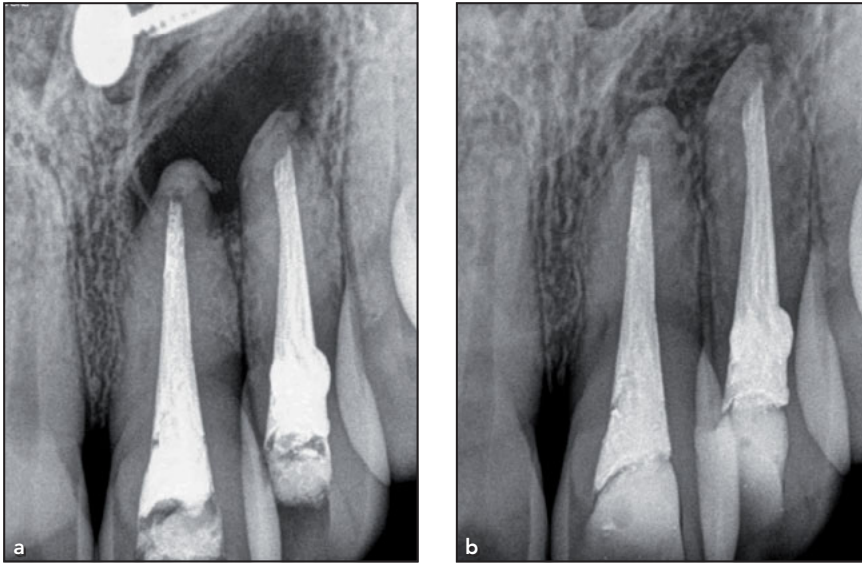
(a) Preoperative radiograph showing the periapical bone defect. (b) 1-year recall radiograph showing bone fill in the periapical bone defect.
